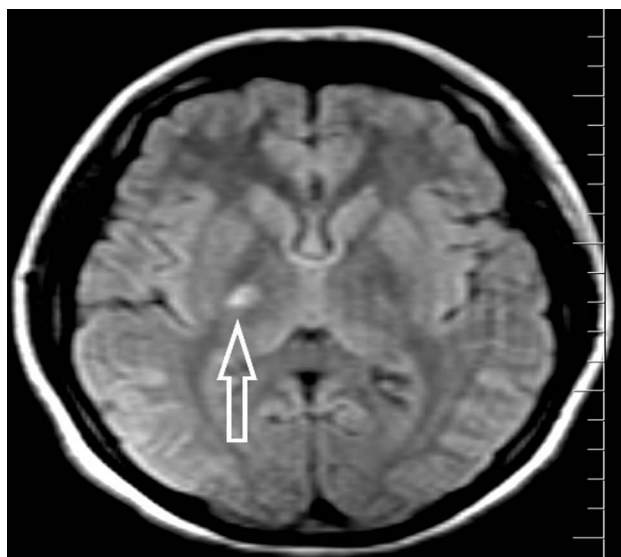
Increased signal in the area of the ventral posterolateral and ventral lateral nuclei of right thalamus in fluid attenuating reversal recovery (FLAIR) sequence compatible with subacute infarction.
